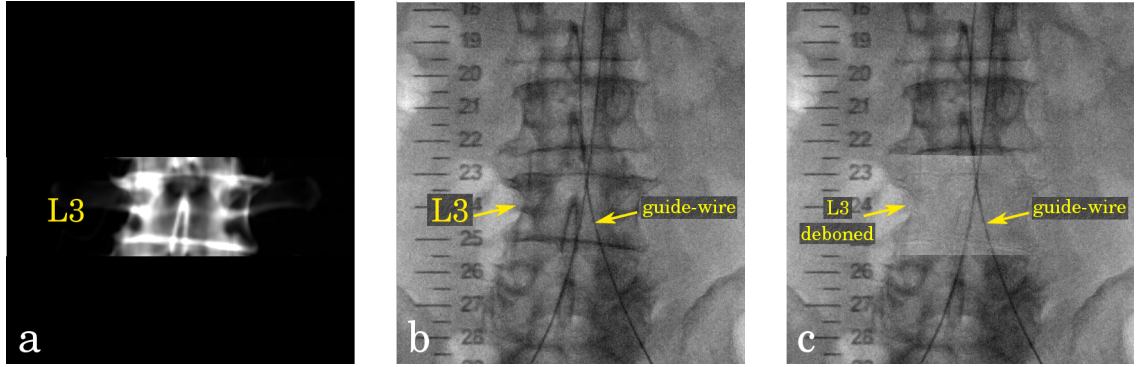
Vertebra removal using the produced DRR at the registration position prior to iDTS reconstruction. a) DRR of an automatically segmented L3 vertebra from the preoperative CT volume at registration position. b) Fluoroscopy image before, and c) after deboning L3.
